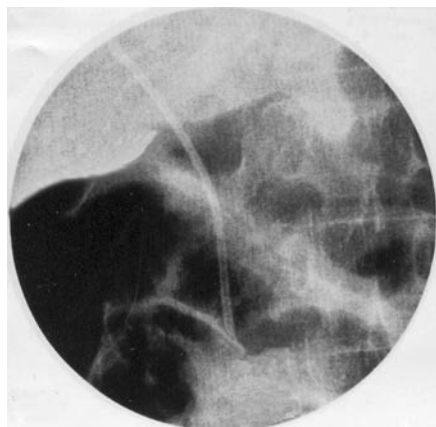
Radiograph of the right upper abdomen showing a migrated stent with dilated loops of intestine.
